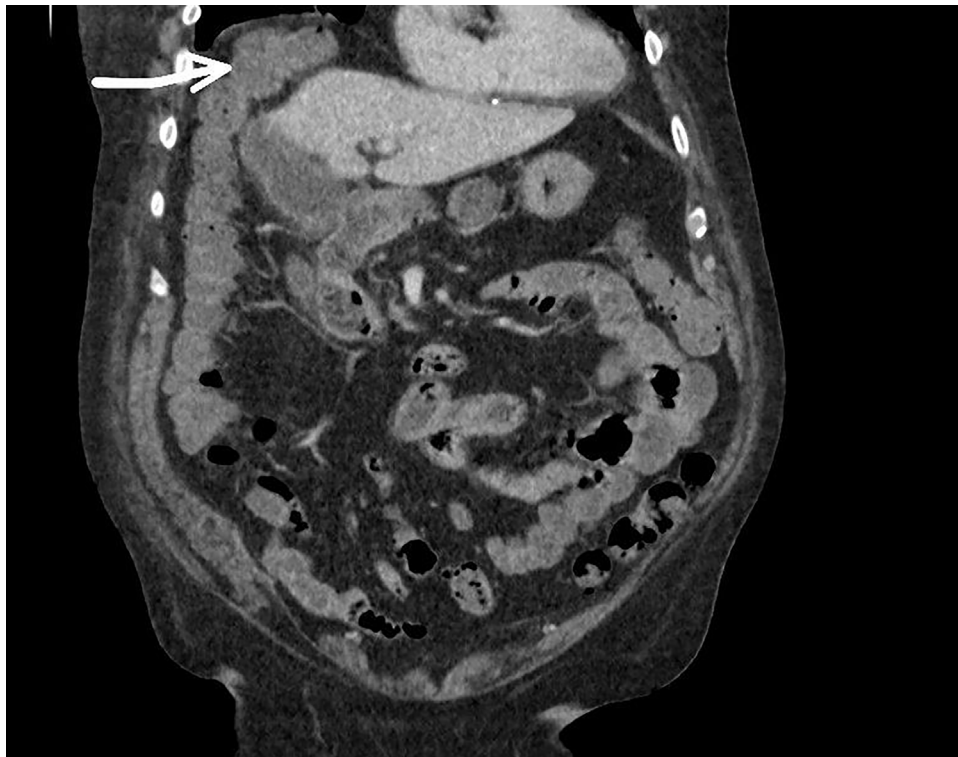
Routine breath-hold, heavily T2-weighted axial CT scan of the abdomen and pelvis identified a bowel loop under the right hemidiaphragm anterior to the liver.
